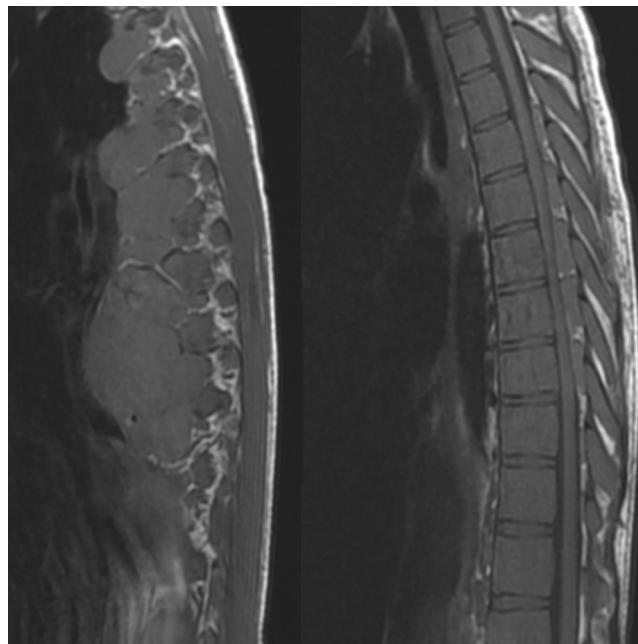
A thoracolumbar MRI scan revealed spinal cord compression due to paravertebral and epidural masses at the level of T5-T9, associated with signs of myelopathy at T9; the paravertebral mass measured 6.8 cm × 5.1 cm on the axial plane. The lumbar spinal cord displayed multiple nodules compressing the thecal sac, compatible with extramedullary haematopoiesis.
